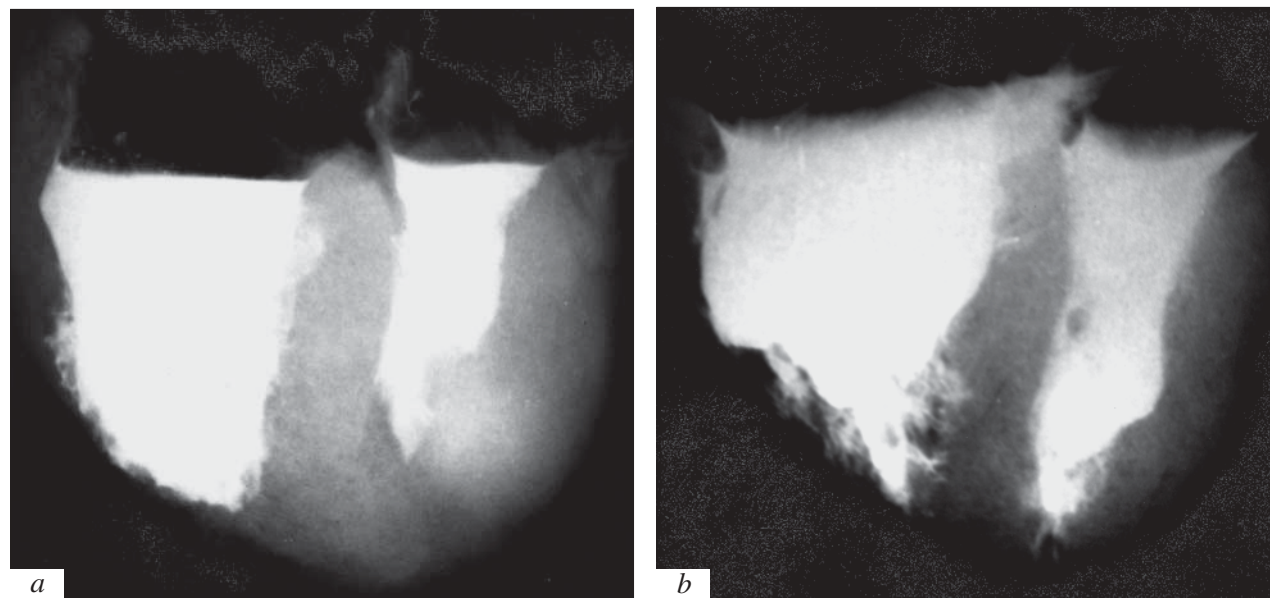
Volume-increasing reconstruction of the right ventricle during combined remodeling of postinfarction heart. Postmortem contrast cardioventriculography. X-ray films, 3-fold demagnification. Pronounced hypertrophy of left ventricular walls and interventricular septum, decrease in the size of its cavity, and sacculate aneurysm. The volume of the right ventricle 3-fold surpasses that of the left ventricle (patient G., 52 years, a; patient N., 58 years, b).
